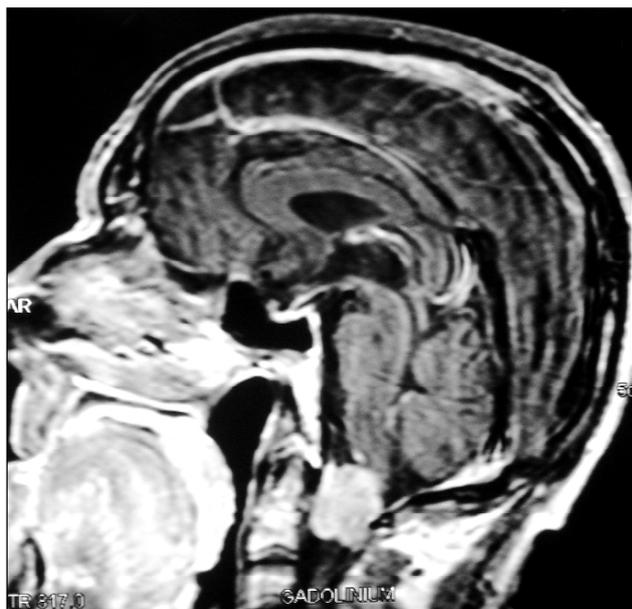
Preoperative T1 sagittal magnetic resonance imaging with gadolinium enhancement showing an intradural mass lesion enhancing homogenously in the region of foramen magnum.
